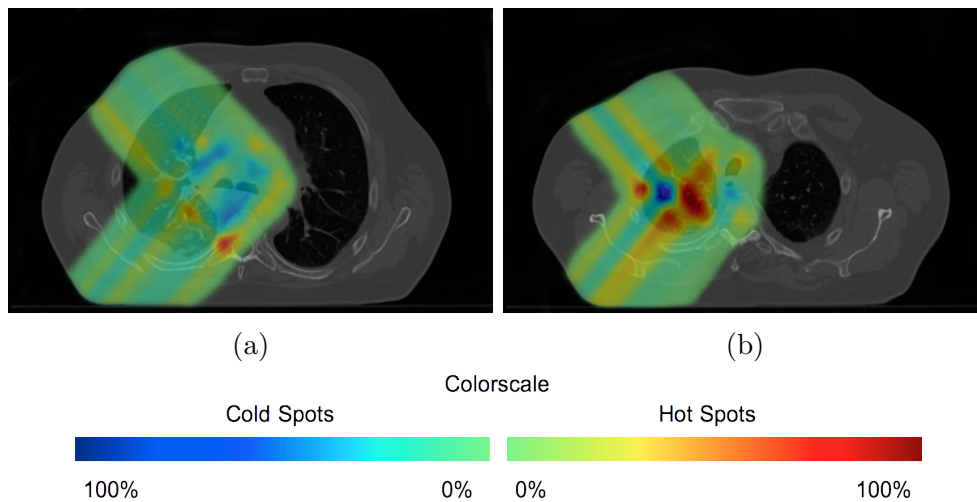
Hot and cold spots present in the dose distribution of the moving patient overlaying the patient CT image (transverse planes). They correspond to the dose distributions in Figure 4.14. Slice 4.15a is located near the middle of the tumor and slice 4.15b is located at a border of the tumor.
